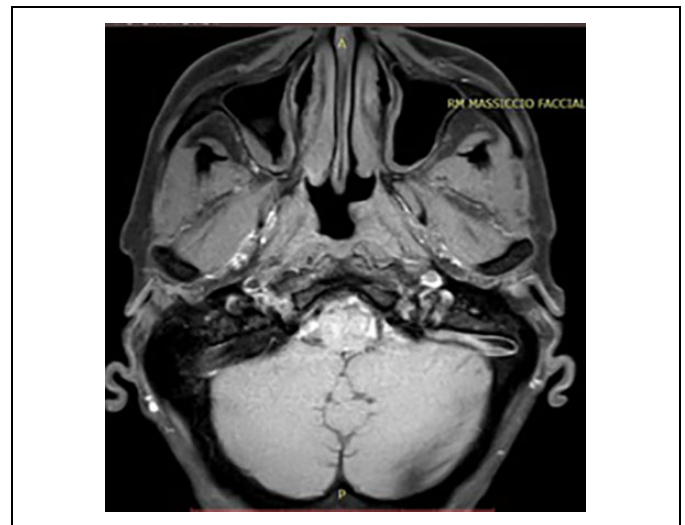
Magnetic resonance imaging (MRI) with contrast after 6 months by treatment.
